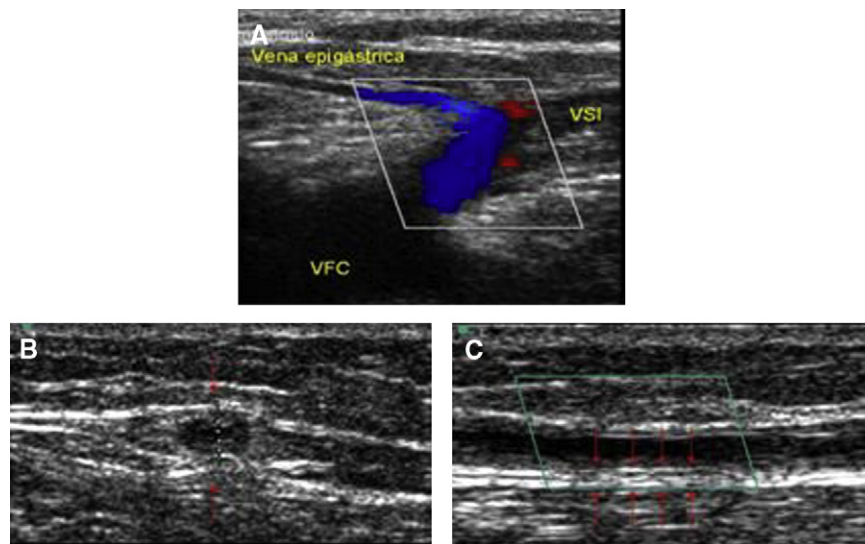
Ultrasonography pattern after endovenous radio-frequency ablation: (A) Patent epigastric vein without flow in the great saphenous vein, (B) Echogenic pattern showing occlusion of the great saphenous vein, and (C) Increase of wall thickness.
